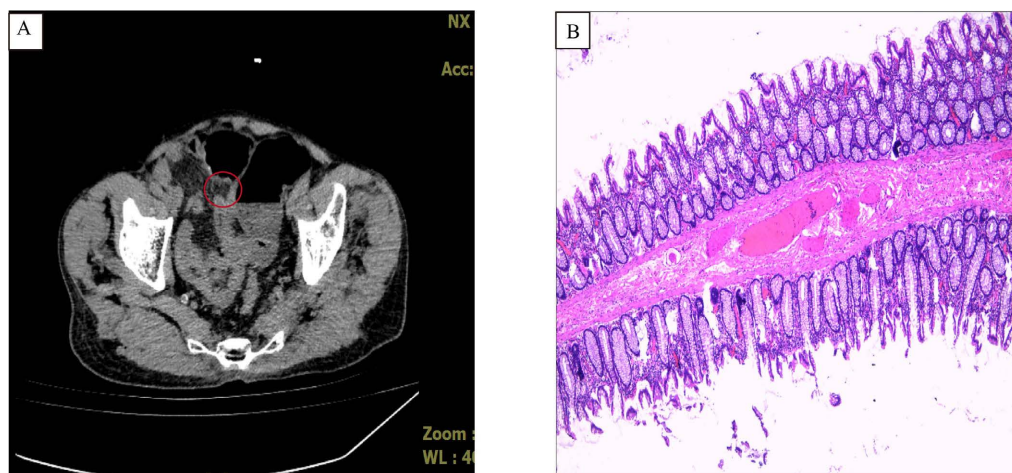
(A) Enhanced CT, (B) Postoperative pathological examination of some colon tissues (4 × 10)
